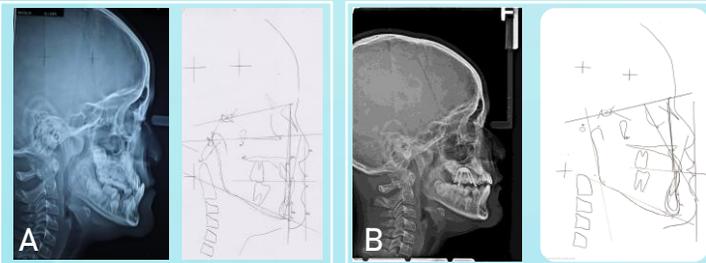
Cephalometric radiography and tracing; (A) before treatment ; (B) After 2 months treatment
